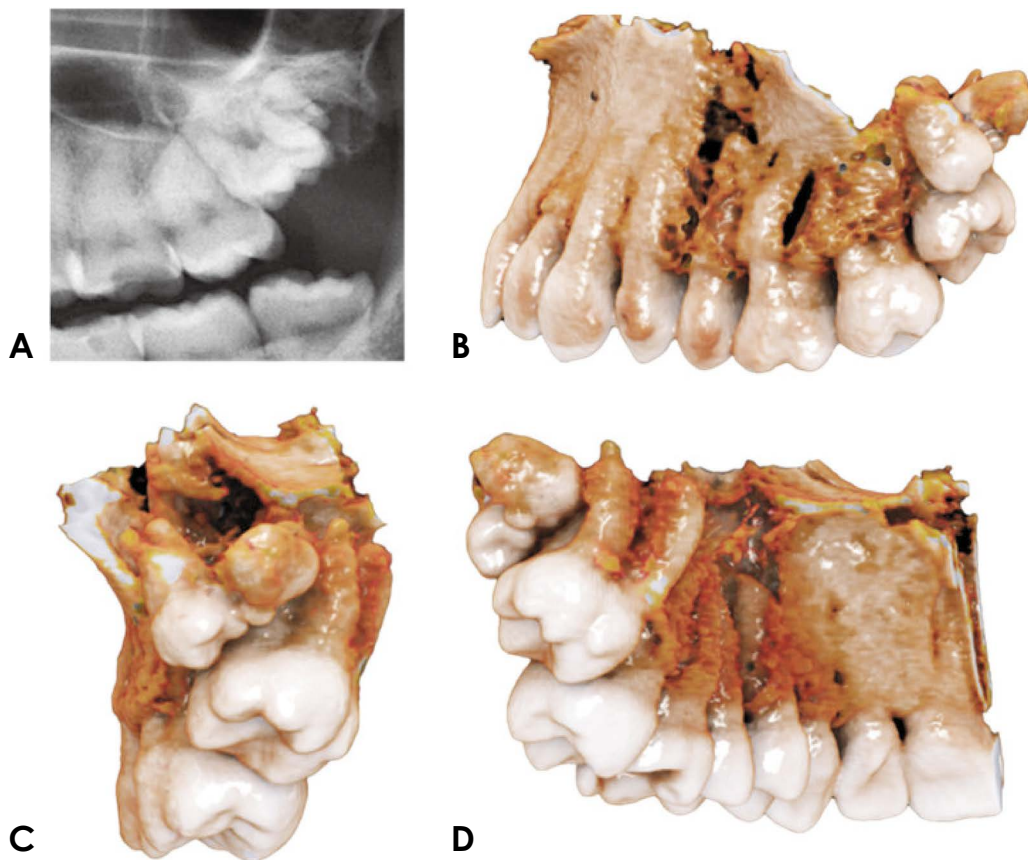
A. Cropped panoramic radiograph of the maxillary molar region. Sagittal (B) and coronal (C and D) photorealistic 3-dimensional reconstruction images of the patient’s cone-beam computed tomography using cinematic rendering.
